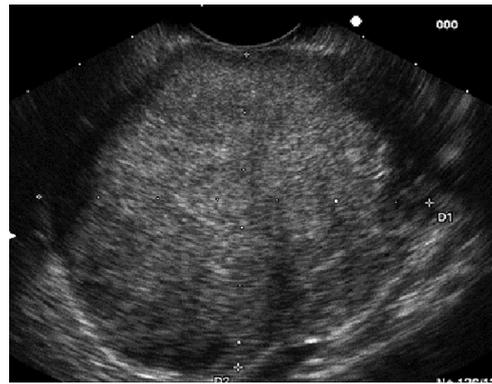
Endoscopic ultrasound image (EUS) showing a mass in body and tail of the pancreas.
